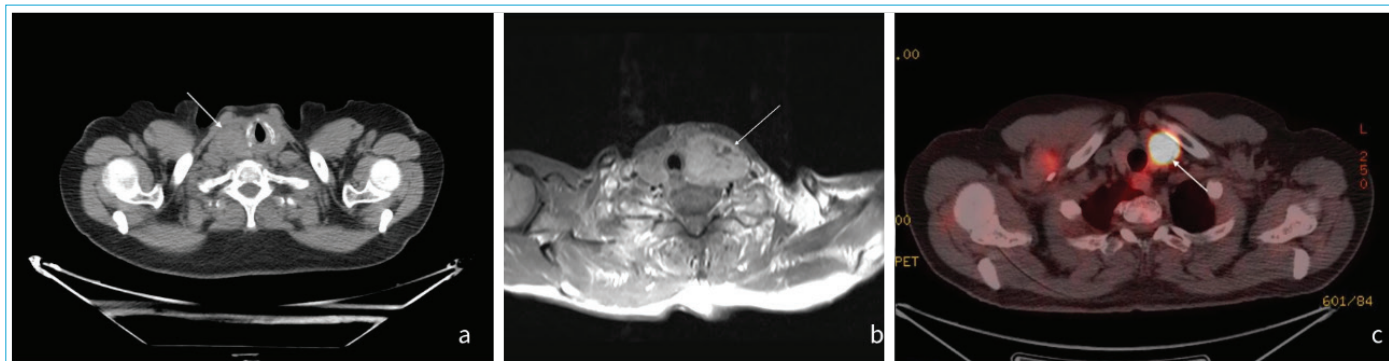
(a) An incidental thyroid nodule (white arrow) causing tracheal deviation in computed tomography scan. (b) An incidental thyroid nodule (white arrow) causing tracheal deviation in T1-weighted image in magnetic resonance imaging. (c) An incidental thyroid nodule (white arrow) with increased 18-Fluoro-Deoxyglucose (FDG) uptake in FDG-Positron Emission Tomography/Computed Tomography.
